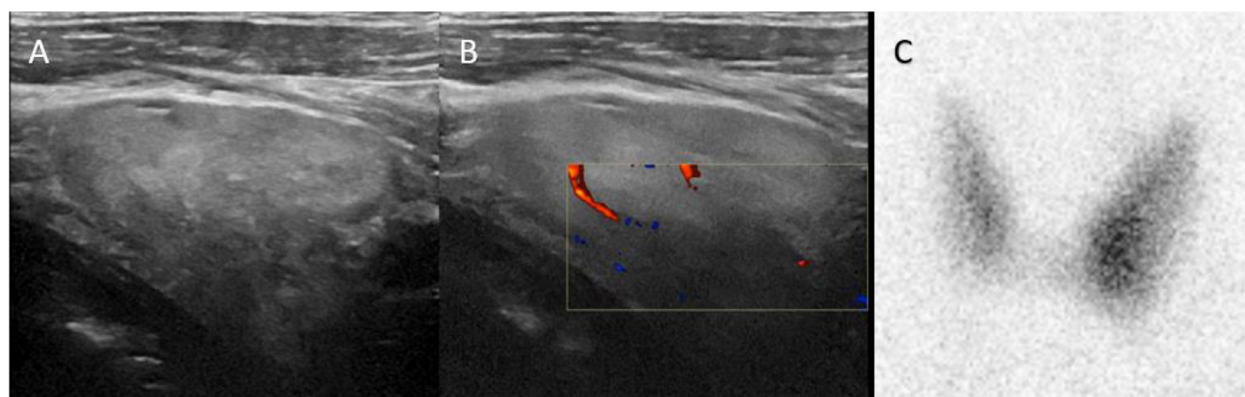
(A) Sagittal grayscale ultrasound reveals the presence of an inhomogeneous process in the caudal region of the left thyroid lobe. The sagittal dimensions of the observed abnormality were approximately 4.3 × 2.7 cm. (B) Sagittal colour Doppler images do not show any discernible pathological blood supply associated with the observed abnormality. (C) Thyroid scintigraphy presents a mildly heterogeneous uptake in the left thyroid lobe, but with no definite cold or hot areas corresponding to the nodule identified by ultrasound in the caudal region.
